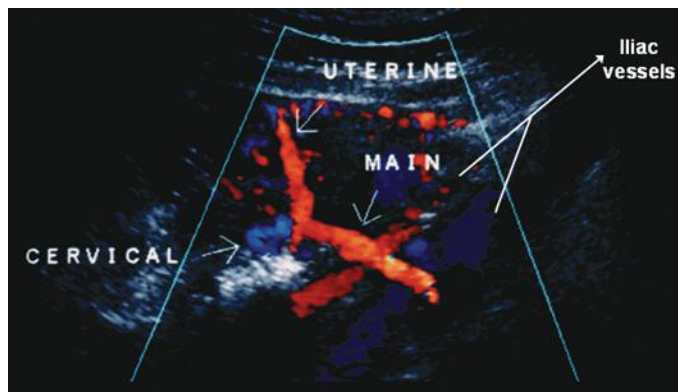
Color Doppler imaging in the lateral lower uterine segment showing the main uterine artery as it crosses over the hypogastric iliac vessels before it enters the uterus and then divides into a uterine branch and a cervical branch.
